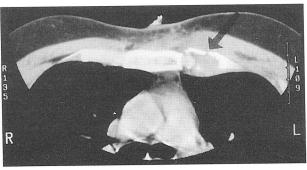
Chest CT scan demonstrating the excavated rib (arrow).
